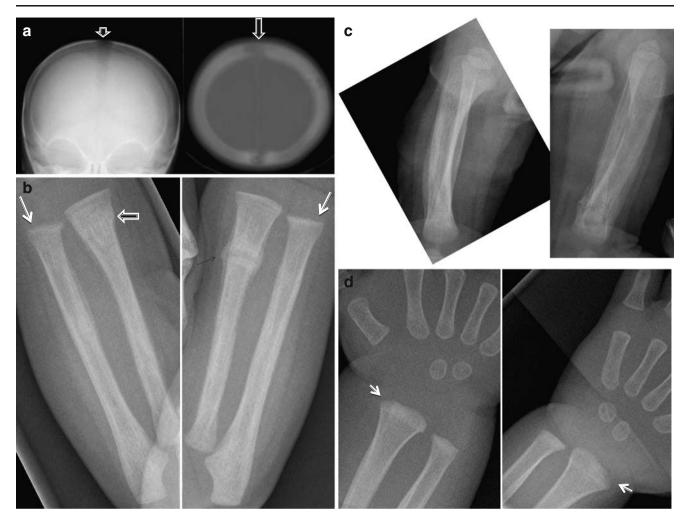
Case 3, a 4-month-old Caucasian male. a Skull imaging. AP plain radiograph demonstrates a diastatic-appearing sagittal suture with poorly defined margins (*small arrow*). Axial CT image (bone algorithm) demonstrates that the demineralization along the sagittal suture (*large arrow*) and not diastasis is causing this radiographic appearance (i.e. pseudodiastasis). Brain CT scan showed no intracranial abnormality and there were no clinical signs of increased pressure. b AP views of the forearms demonstrate a transverse lucency through the distal radial diaphysis with surrounding sclerosis (*thin black arrow*). A lack of symptoms, angulation or displacement is important in differentiating fractures from Looser zones. There is a buckle fracture in the right distal radial metadiaphysis (*white outlined arrow*). Note the indistinct appearance of the distal ulnar metaphyses (*long*
